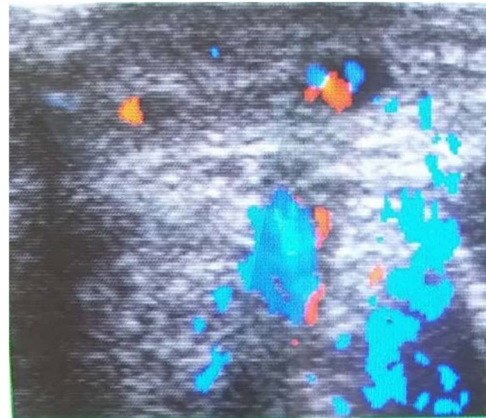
The cross section image of doppler ultrasound demonstrates superficial vascular structure in the skin lesion of the neonate.
